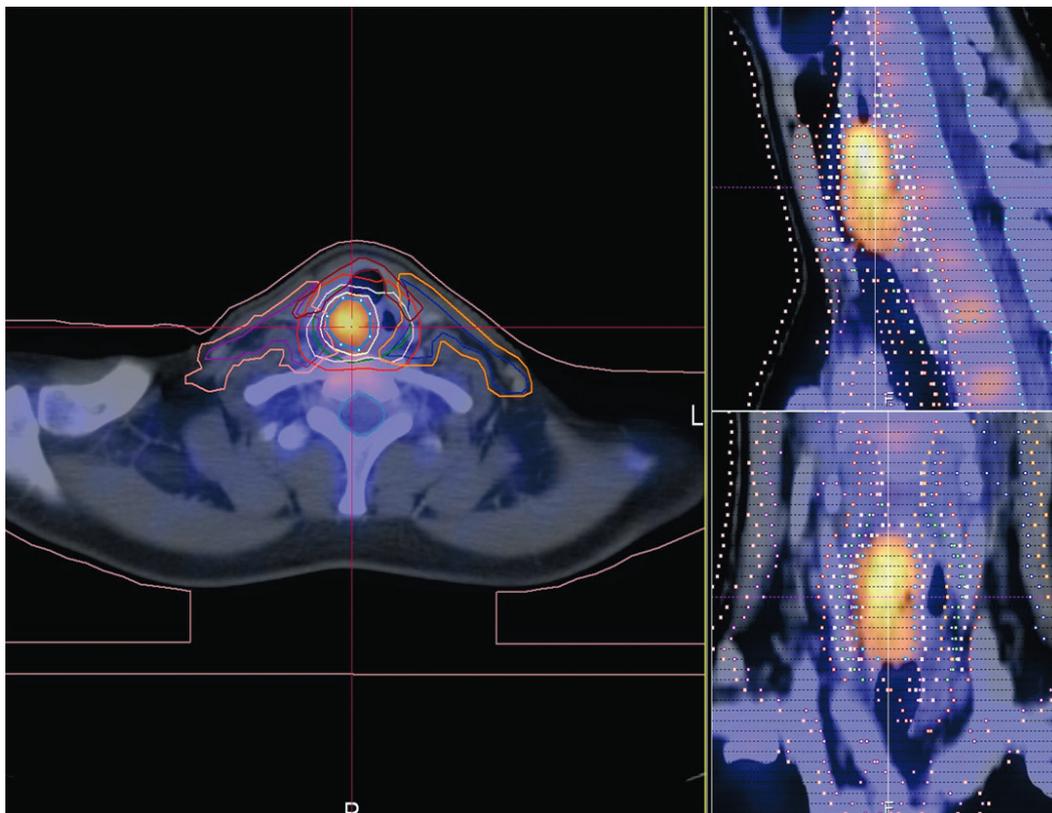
Differences in radiation volume estimation between CT and PET-CT
